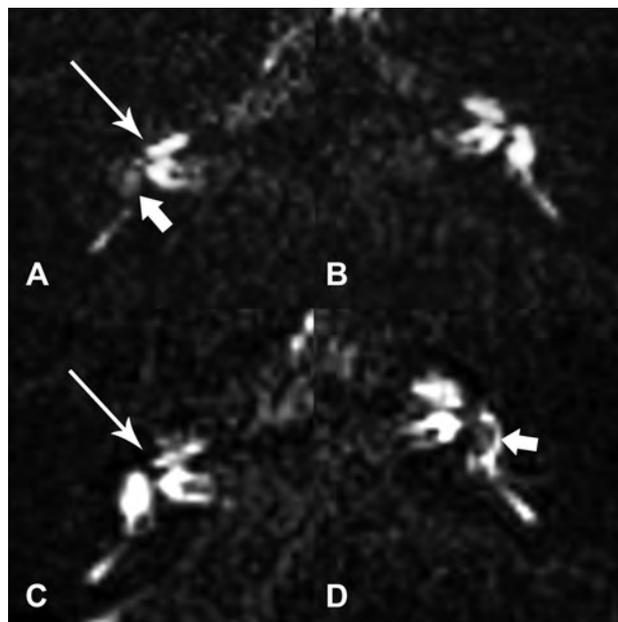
Initial and follow-up studies in a patient with unilateral right MD that progressed to bilateral disease. A and B, Initial MR imaging shows hydrops involving the right vestibule (*short arrow*) and cochlea (*long arrow*). There is increased perilymph signal intensity in both ears, but the left ear (B) is asymptomatic and shows no hydrops. The patient underwent right vestibular neurectomy, with improvement in symptoms. C and D, Follow-up study 18 months after A and B, performed because of new symptoms of aural fullness in the left ear, shows new hydrops involving the left vestibule (*short arrow*). Hydrops in the right vestibule has improved, though there is persistent hydrops in the right cochlea (*long arrow*).
